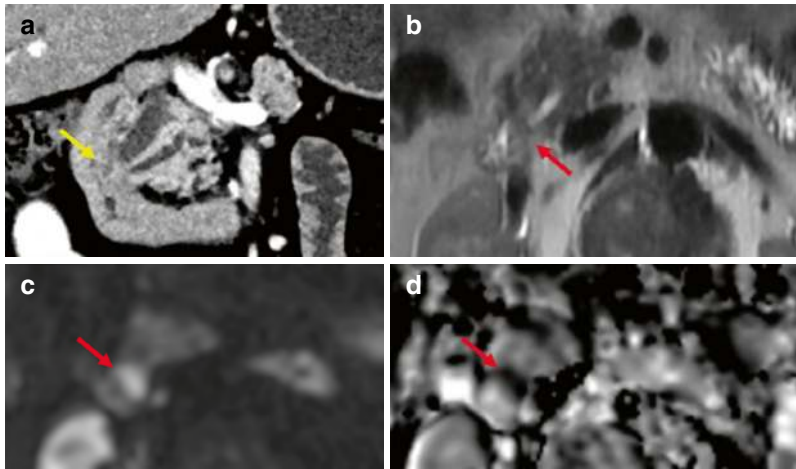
A 55-year-old male with jaundice. (a) Oblique coronal image of CT shows slightly bulky ampulla with a small equivocal isoenhancing mass in the periampullary region due to inadequate duodenal distension. MRI (b)
